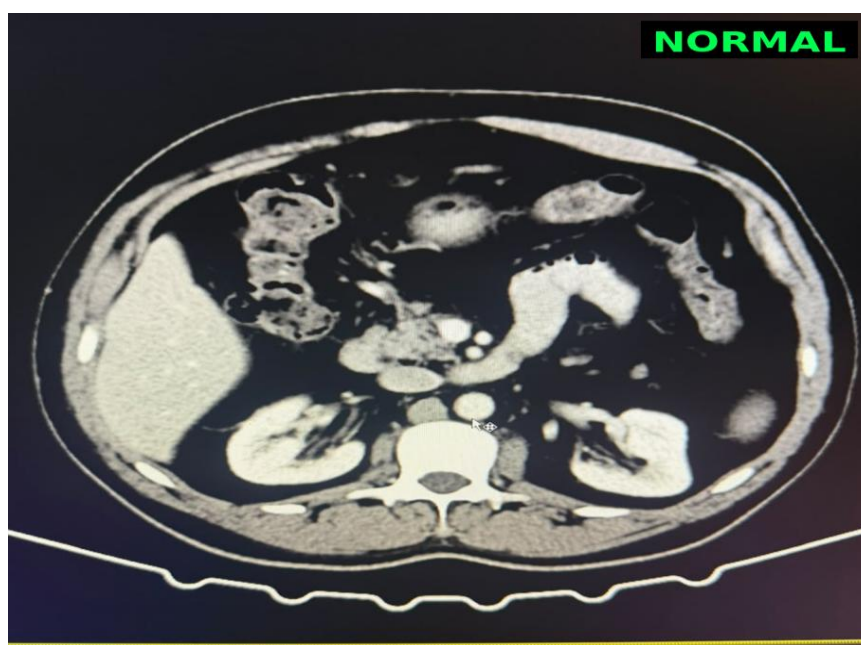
Axial contrast-enhanced CT from a comparison subject with normal venous anatomy.
